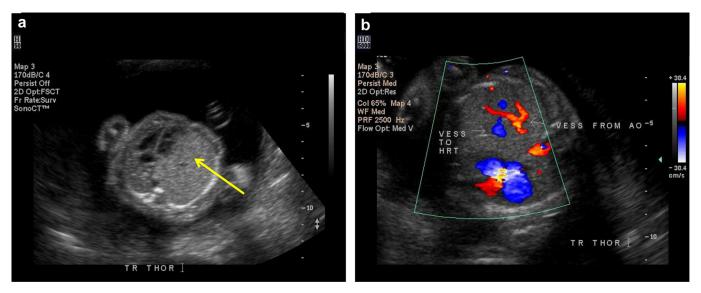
a and b: Prenatal ultrasound images. The yellow arrow shows the large mass occupying the left hemithorax.
